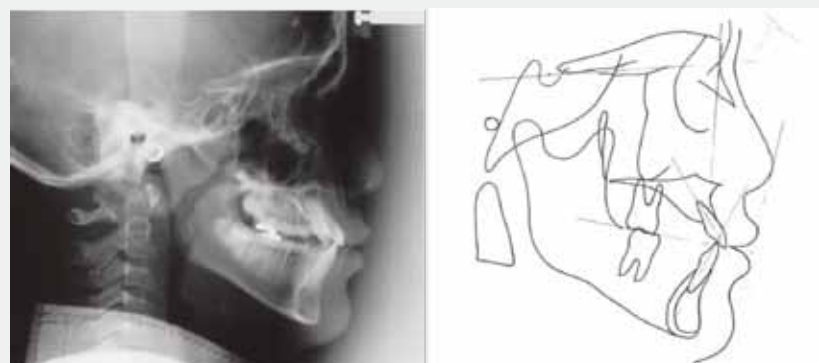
Case 2, pretreatment cephalometric radiograph and tracing
